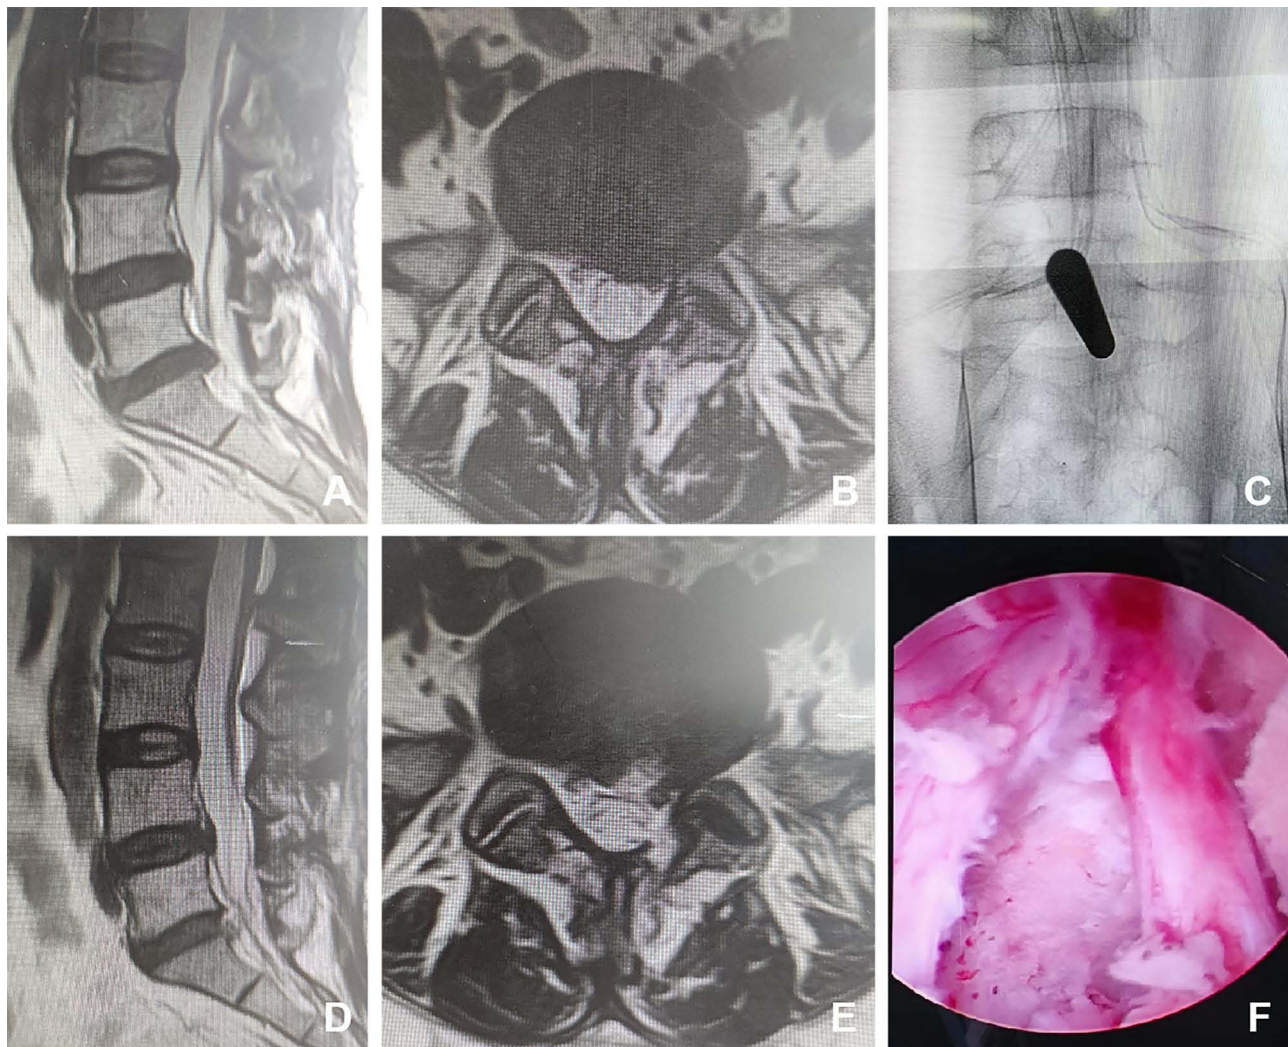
Female, 50 years old, L5/S1 lumbar disc herniation. (A) Preoperative sagittal MR image showed L5/S1 lumbar disc herniation; (B) Preoperative axial MR image showed herniated lumbar disc compressed nerve root and dural sac; (C) Intraoperative fluoroscopic confirmation of metal rods; (D) Postoperative sagittal MR image revealed the complete decompression of the spinal canal; (E) Postoperative axial MR image showed the complete removal of herniated disc and bony fragment; (F) Intraoperative image after complete neural decompression.
